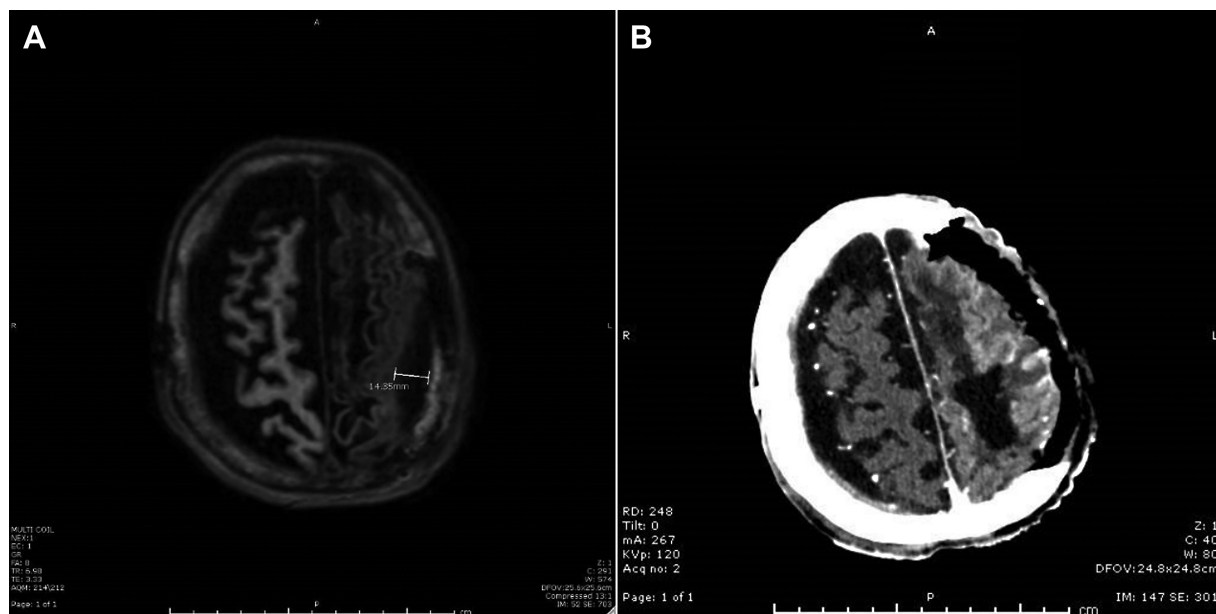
Brain axial view T1 magnetic resonance imaging with IV contrast showing left frontal epidural and subdural empyema measuring about 1.4 cm in its maximum thickness, associated with a hypodense area involving the underlying left frontal lobe suggesting for encephalitis, the left frontal lobe appears edematous with effacement of the sulci and leptomeningeal enhancement. Fig. 2B Brain computed tomography scan with IV contrast showing interval resolution of the previously noted left frontal convexity empyema with a large area of pneumocephalus at its site. The left frontal lobe appears edematous with effacement of the sulci and leptomeningeal enhancement, suggesting for encephalitis.
